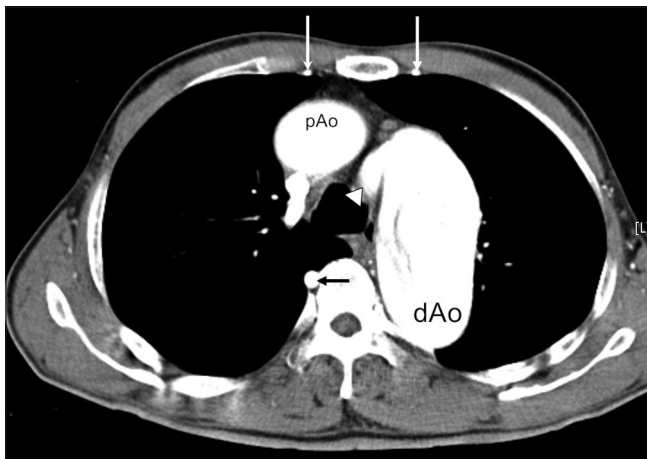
Contrast-enhanced transaxial computed tomography image demonstrates the aortic dissection started just after the discrete coarctation that was connected from the tubular hypoplasia (white arrowhead). There were collateral vessels of dilated internal mammary arteries (white arrows) and intercostal artery (black arrow). pAo: Proximal portion of aortic arch, dAo: Distal portion of aortic arch
